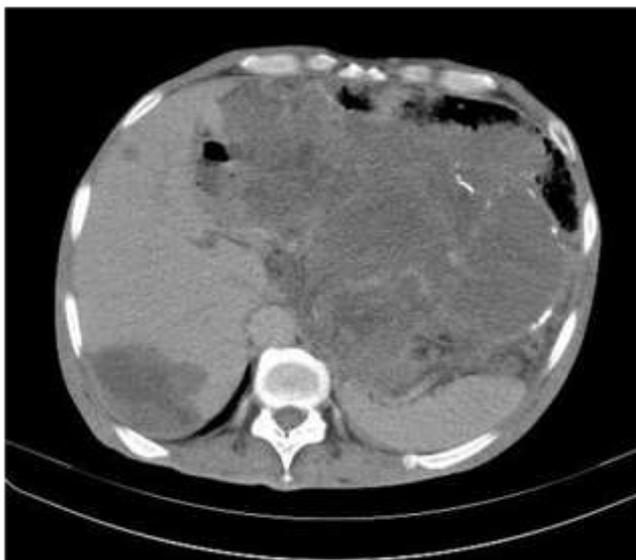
Axial CT scan showing a large heterogeneous mass of the left flank with two liver lesions.
